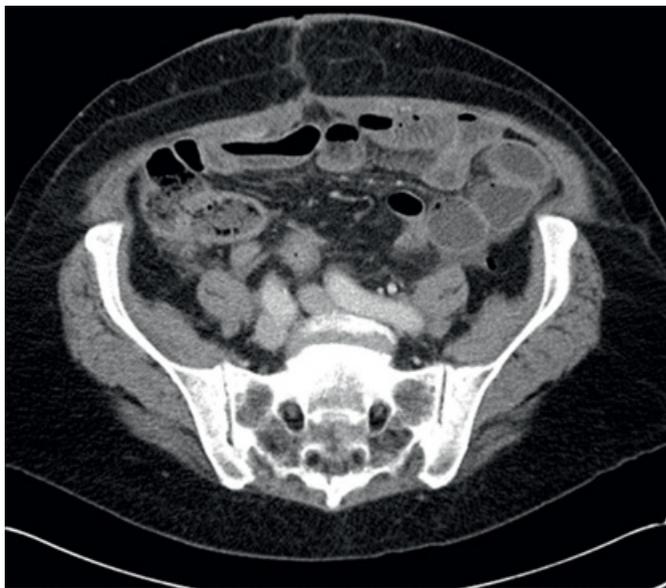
CT scan of abdomen showing dilated loops of small intestine with air–fluid levels and contrast passing through descending colon.
